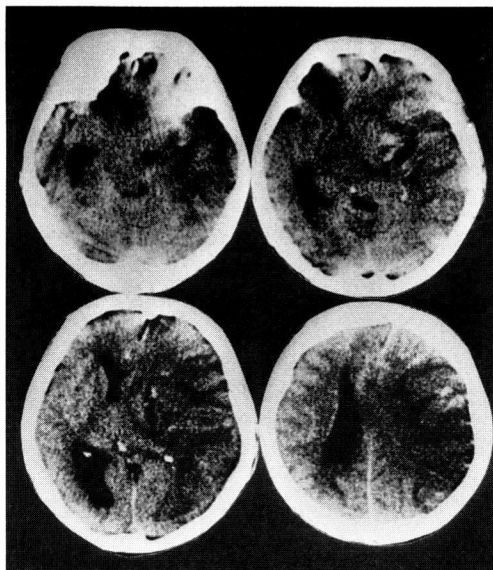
A CT scan of Case 3, showing hemorrhagic infarction in the distribution of the right middle cerebral artery with transtentorial herniation.
